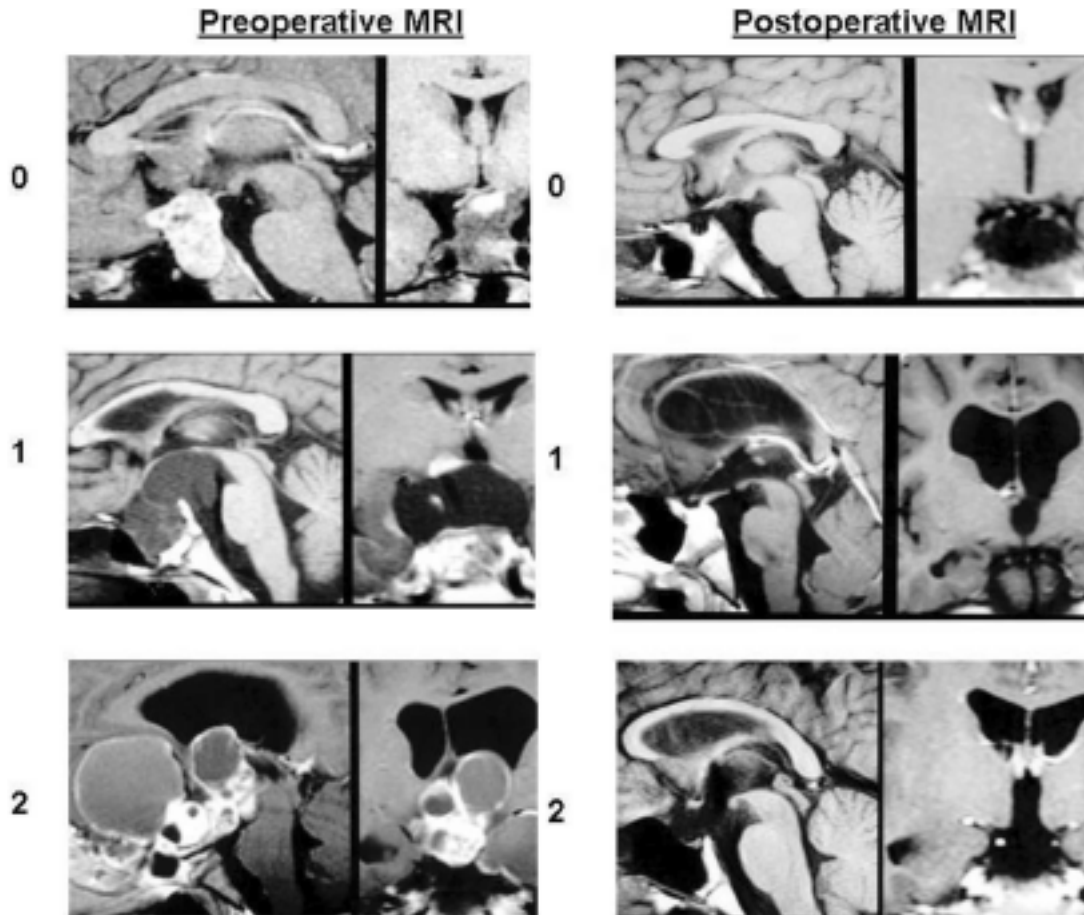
Preoperative (left column) and postoperative (right column) MR imaging classification of pediatric craniopharyngiomas. *Upper Left:* Grade 0, no hypothalamic involvement. *Center Left:* Grade 1, hypothalamus displaced by the tumor. *Lower Left:* Grade 2, hypothalamic involvement. *Upper Right:* Grade 0, no hypothalamic damage. *Center Right:* Grade 1, minimal hypothalamic damage. *Lower Right:* Grade 2, severe hypothalamic damage.
